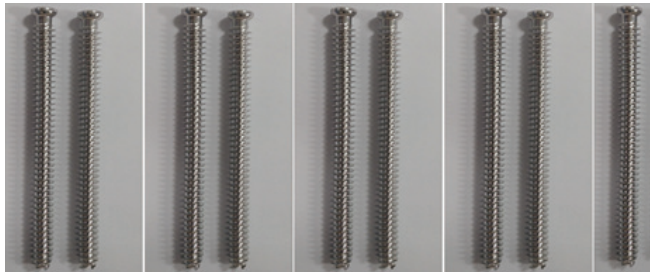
(a). Actual images of manufactured cannulated screws before ultrasonic cleaning
